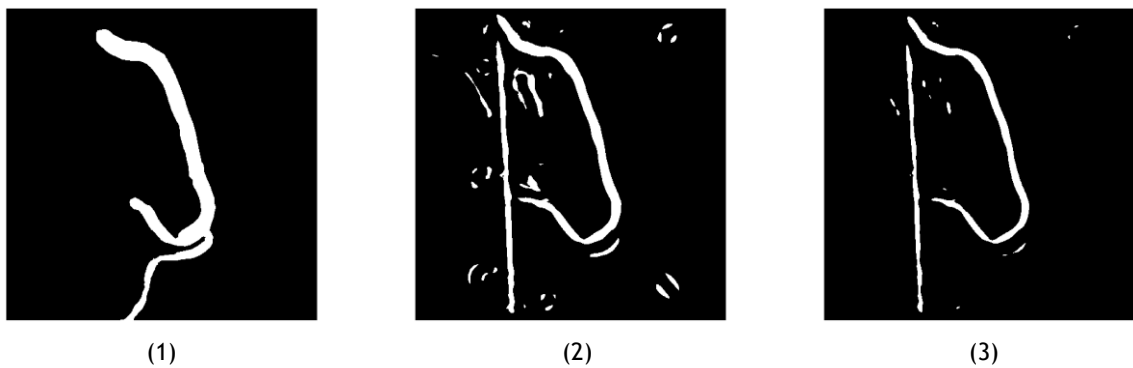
Manual mask (1), automatic mask corresponding to threshold t_1 (2) and automatic mask corresponding to threshold t_2 (3) for X-ray 1. For the remaining X-rays the same figures are shown in Appendix E.
